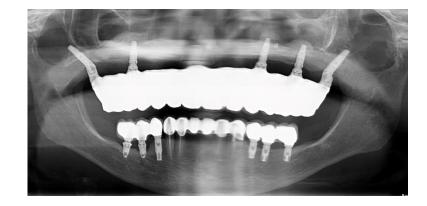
X-ray at 2-year follow-up.
